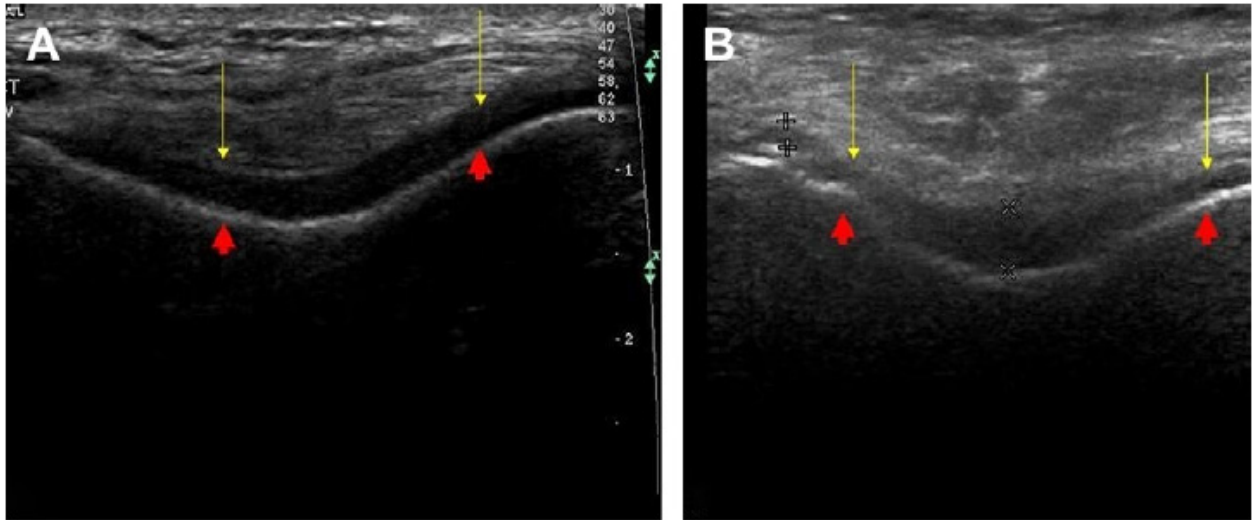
OA of the knee. Coronal ultrasound scans through the distal femur of a normal knee (A) and an osteoarthritic knee (B) demonstrate the intracondylar notch. The red arrows indicate the cortical surface of the femur, and the yellow arrows indicate the superficial surface of the cartilage. Note that compared with the normal knee, the cartilage in the osteoarthritic knee is more echoic, there is loss of definition of the margins, and it appears thinner laterally.
